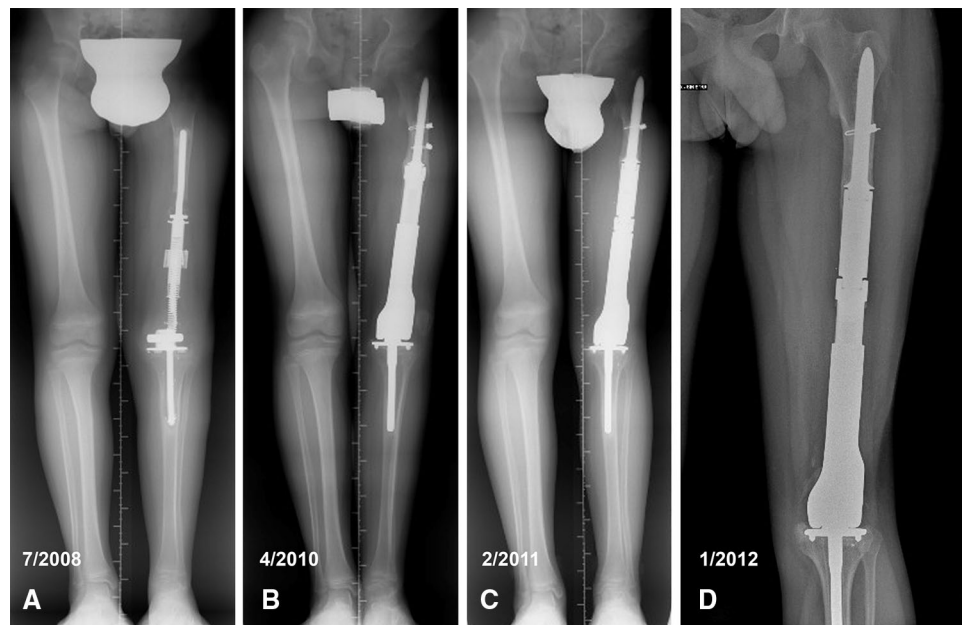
Sequential radiographs show (A) spring breakage of the Repiphysis[®] prosthesis in 2008, followed by (B) revision surgery in 2010 with another type of expandable prosthesis, and radiographic controls after expanding the new prosthesis in (C) 2011 and (D) 2012.
